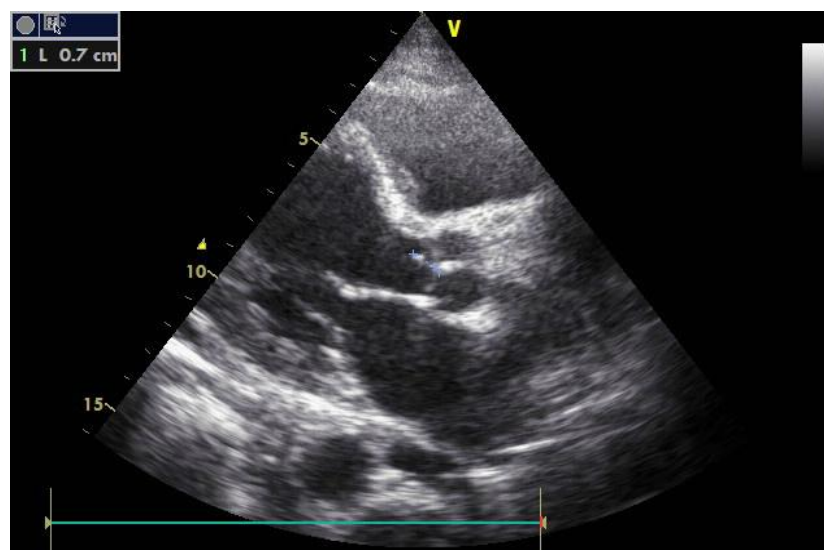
D echocardiography of the heart showing large vegetation on the aortic valve
